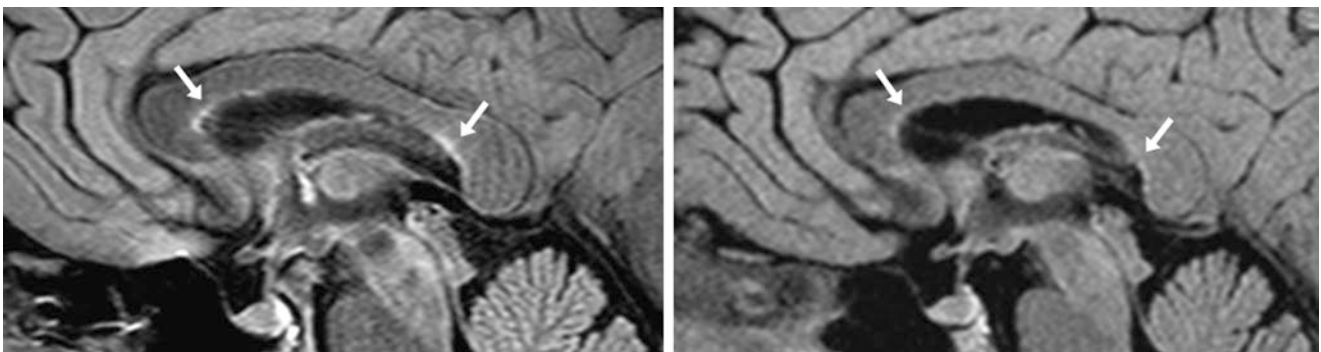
A 37 year old with a 3T MRI that was performed for headaches (interpreted as negative) demonstrating mild, normal hyperintensity anteriorly and posteriorly (arrows) on a midline sagittal FLAIR
